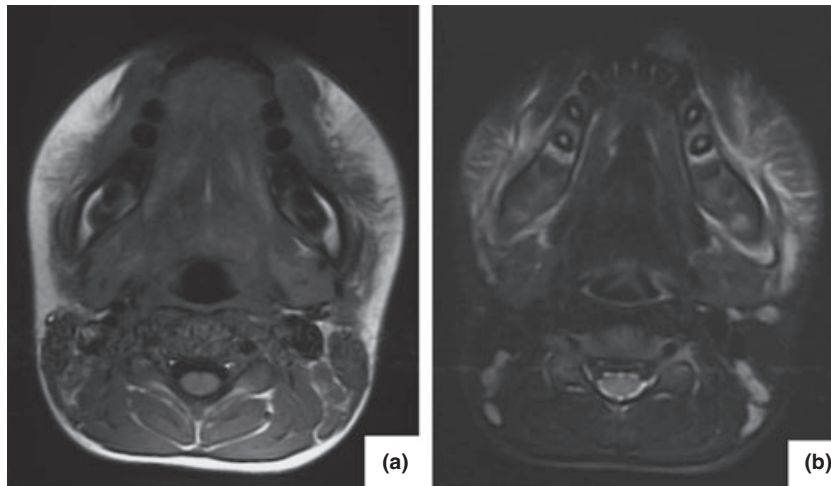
Magnetic resonance (MR) imaging findings of the mental region and lower face 2 days after trauma. MRI (a. T1-weighted images; b. short TI inversion recovery images) shows swelling and an unclear soft tissue margin, as well as cloudy fat tissue around the mental region and the lower face, but no abscess formation.
